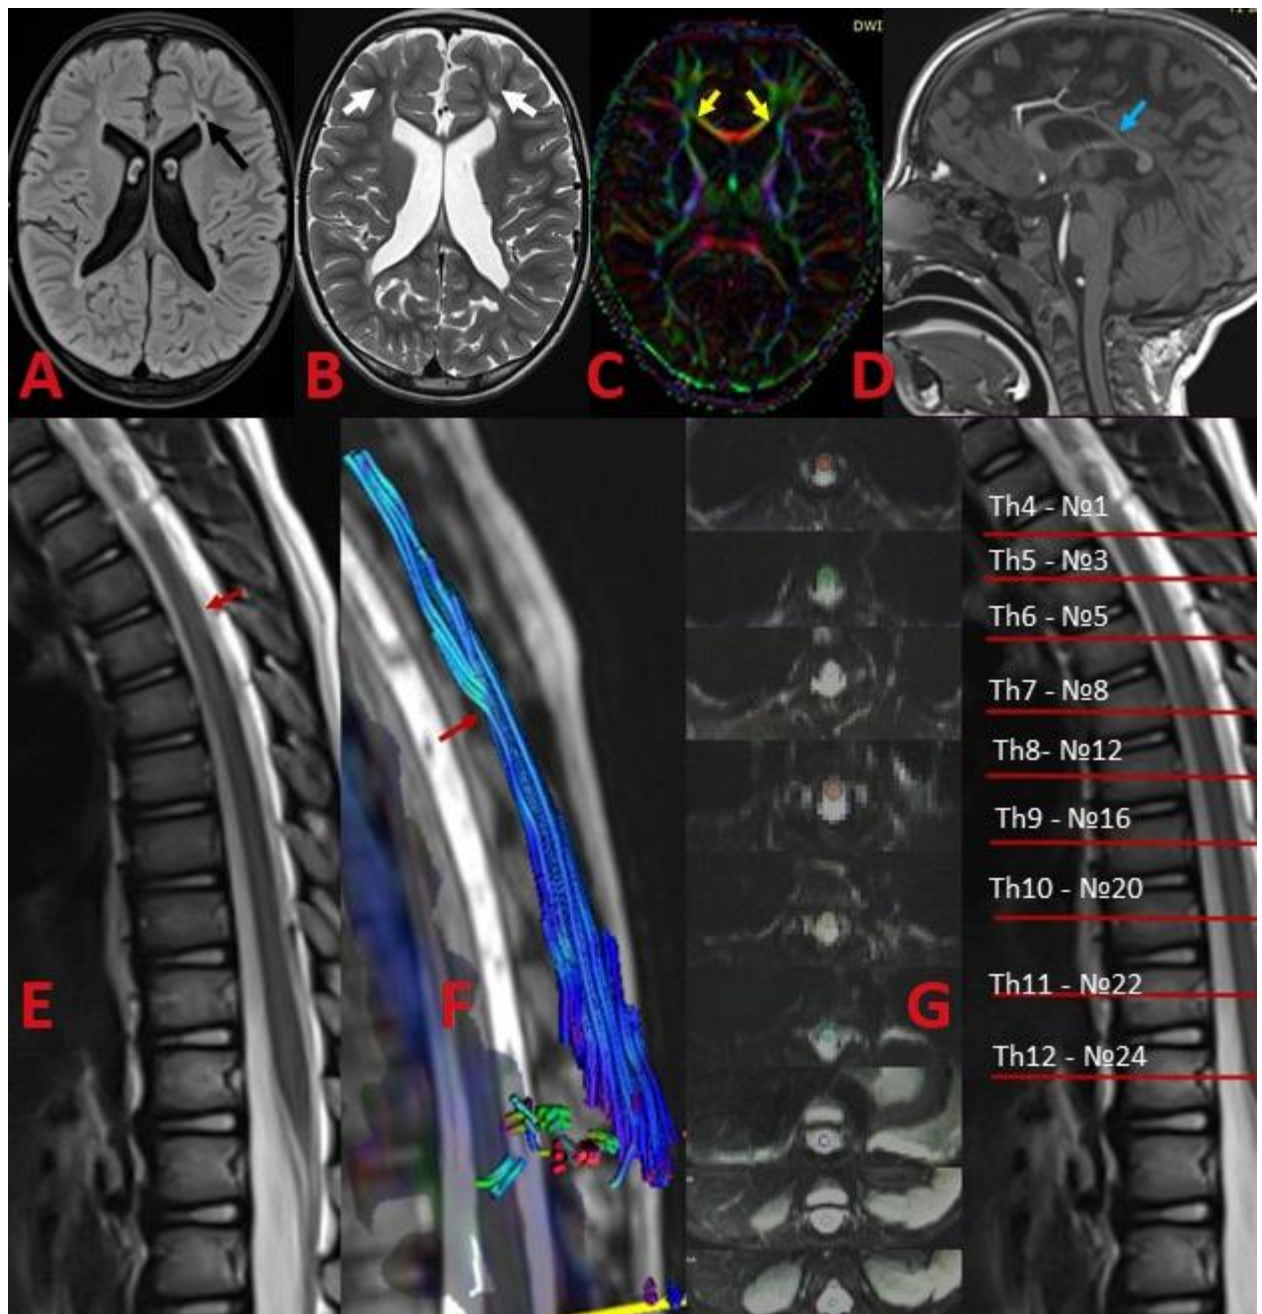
MRI with tractography of brain and spinal cord of patient V. A. T 1-weighted brain axial cut. Black arrow – periventricular areas of gliosis with cystic transformation. B. T 2-weighted brain axial cut. White arrows – periventricular areas of gliosis with cystic transformation, white matter depletion. C. Brain tractography. Yellow arrows - fibers of semioval centers pathways are depleted, cortico – spinal tracts with the signs of Wallerian degeneration. D. T1-weighted brain sagittal cut. Blue arrow - corpus callosum atrophy. E. T2-weighted sagittal spine cut. Red arrow - depletion of spinal conducting pathways. F. Spine tractography. Red arrow - depletion of spinal conducting pathways. G. Those 25 axial spine cuts are indicated, at which the authors have measured fractional anisotropy (FA) and apparent diffusion coefficient (ADC) from the Th4 level down to Th 12 level. (the length of the study field 14 cm)
